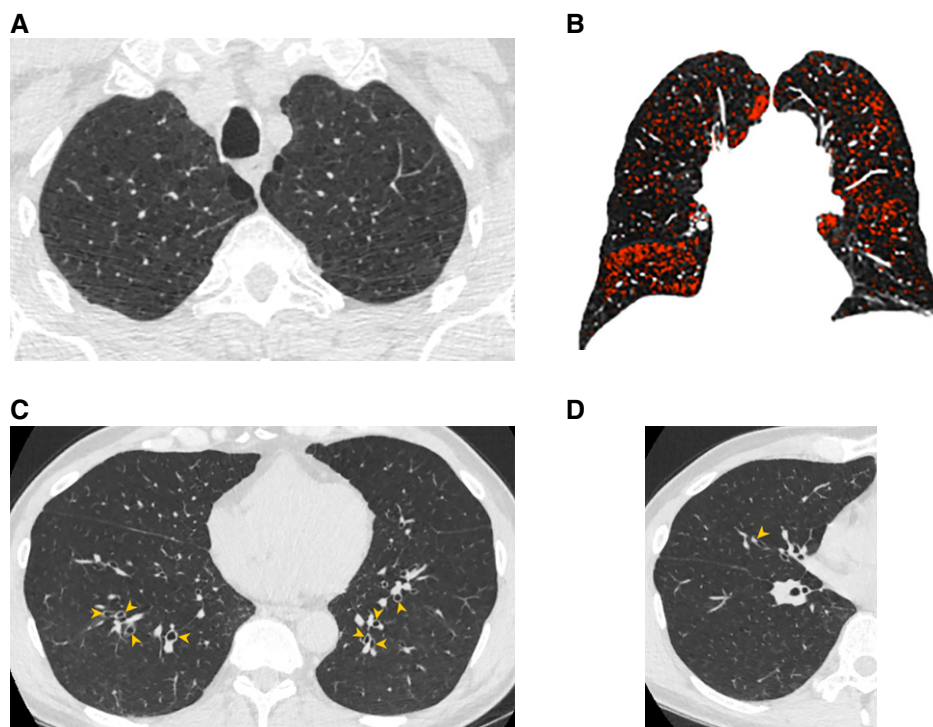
Examples of common chronic obstructive pulmonary disease–related findings on lung cancer screening computed tomography examinations: (A) mild upper-lobe centrilobular and paraseptal emphysema, (B) density map of same patient in A (coronal view) demonstrating that 9% of the total lung volume is affected by emphysema (shown in red) using an attenuation threshold of lower than -950 Hounsfield Units, (C) mild lower-lobe small-airway wall thickening with mild cylindrical bronchiectasis (arrowheads), and (D) subsegmental mucoid impaction (arrowhead) in the right middle lobe.
